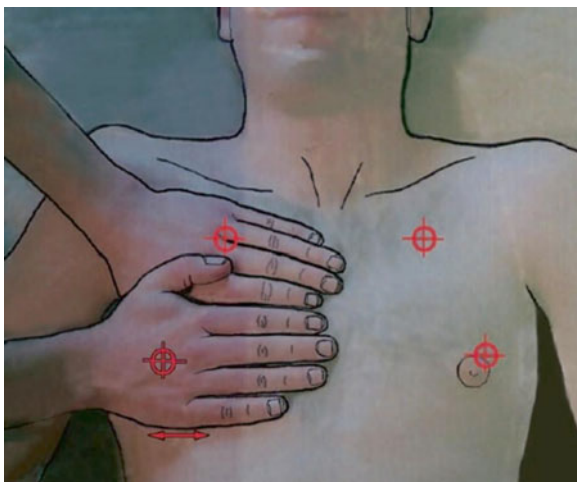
The BLUE points. The upper hand is applied with the little finger against the lower border of the clavicle (in its long axis). The finger tips touch the midline. The lower hand is applied below the first hand. The thumbs do not count. The upper BLUE point is at the base of the middle and ring fingers of the upper hand (upper cross). The lower BLUE point is in the middle of the palm of the lower hand (lower cross). In this subject, the lower BLUE point is near the nipple. This definition makes a symmetric analysis, usually avoiding the heart. The lower edge of the lower hand roughly indicates the phrenic line (*arrow*), i.e., the end of the lung. Note that the shape of the hands has been studied in order to correct the obliquity of the clavicle, yielding a roughly transversal phrenic line (from *Whole Body Ultrasonography in the Critically Ill*, Springer)
